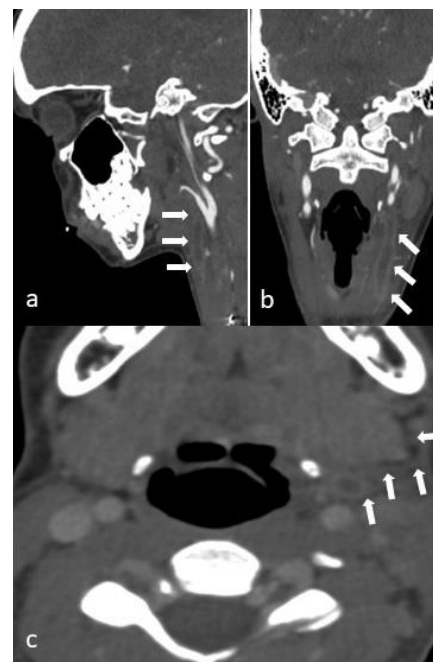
Contrast-enhanced CT of the neck region with axial, coronal and sagittal reconstruction showing a hypoechoic thrombus in the middle and distal tract.
